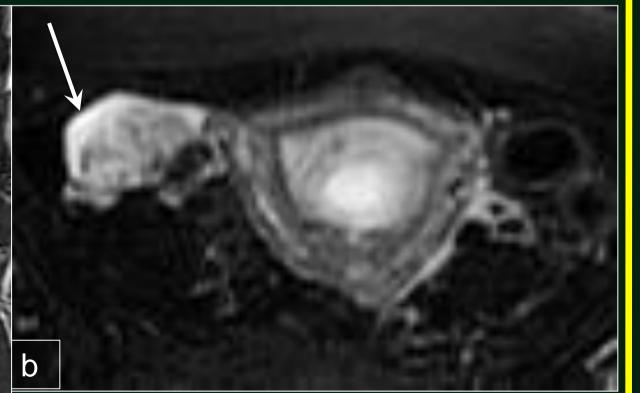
Ovarian torsion. Coronal FIESTA image (a) demonstrates an enlarged right ovary containing multiple cysts (arrowheads). Axial T2-weighted SSFSE FS image (b) exhibits free fluid (arrow) adjacent to the thickened, twisted vascular pedicle.
